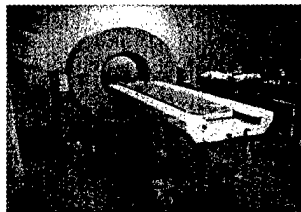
Mobile CT gantry and table.
